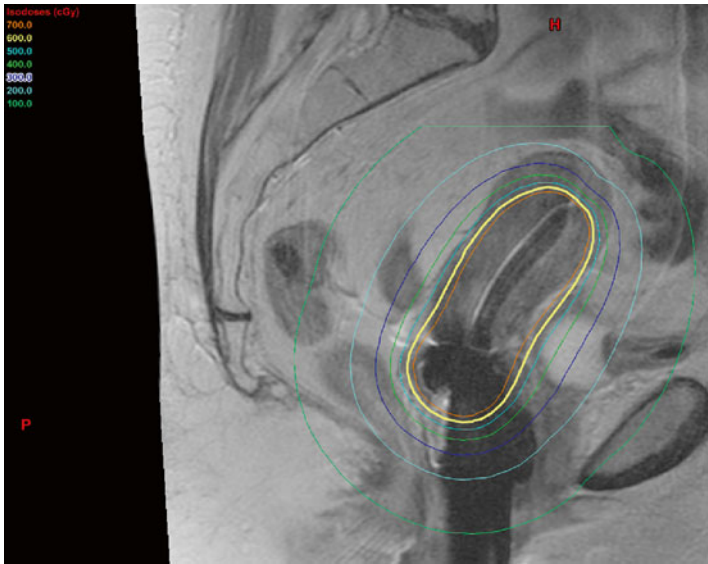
Sagittal MRI display with brachytherapy equipment in place. *Colored lines* represent distribution of dose around the applicator, with dose decreasing as a function of the inverse square law. Image courtesy of C. Yashar.
